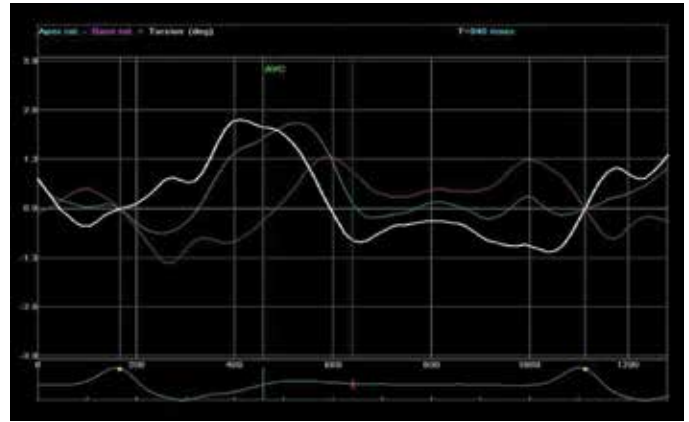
Reduced left ventricular basal and apical rotation and net twist by 2D speckle tracking Echocardiography.
